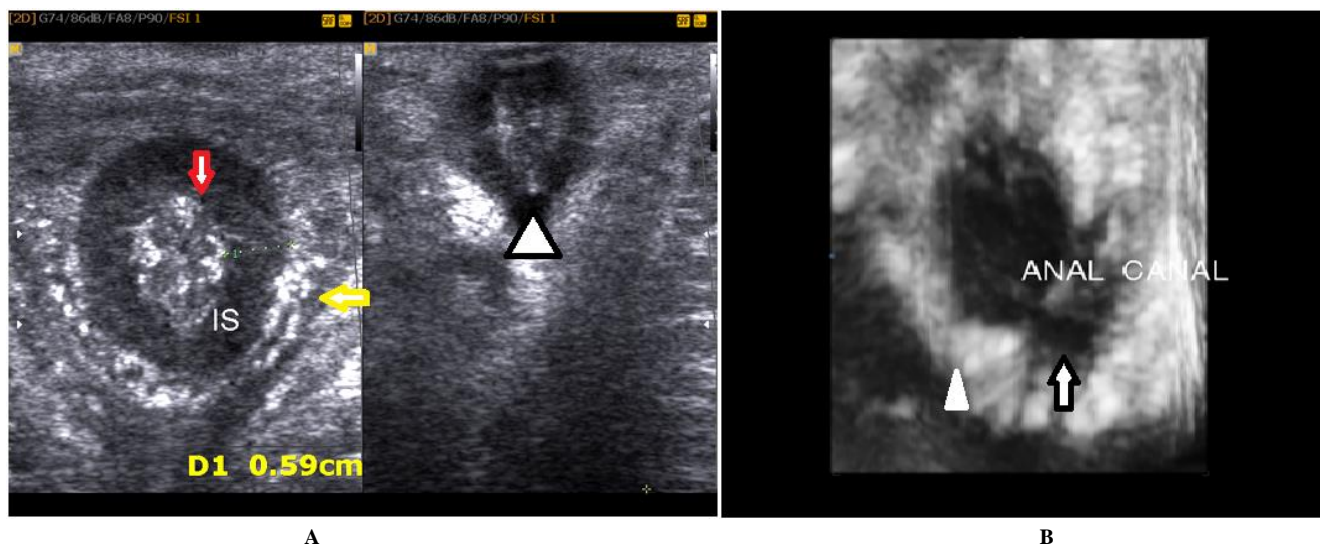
A) 2 dimensional transperineal ultrasound axial images of the anal canal showing thick internal sphincter (IS) with associated lucent defect posteriorly (arrowhead), the yellow arrow points to the external anal sphincter and the red arrow points to the anal mucosa. B) 3 dimensional surface rendering of the internal anal sphincter showing posterior lucent defect (arrow) and arrowhead indicates the internal anal sphincter.
